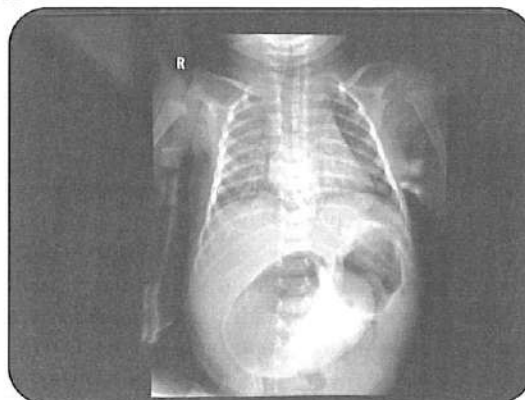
Abdomial X-ray with the double bubble sign
